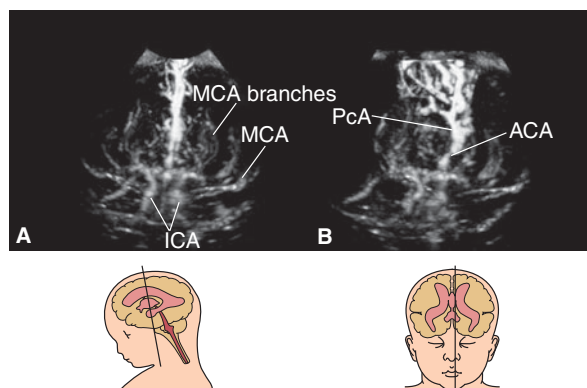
Conventional 3D power Doppler image of fetal brain circulation. (A) Cranial view. The bilateral internal carotid arteries (ICA) and middle cerebral arteries (MCA), as well as the branches of MCA, are demonstrated. (B) Anterior oblique view. The anterior cerebral artery (ACA) and the pericallosal artery (PcA) are demonstrated.
